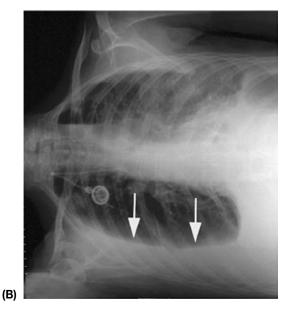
(A) Upright chest radiograph showing a right pleural effusion (arrows). (B) Right lateral decubitus film of the same patient in (A) shows that the effusion is free flowing and provides better quantitation of the size of the effusion.
